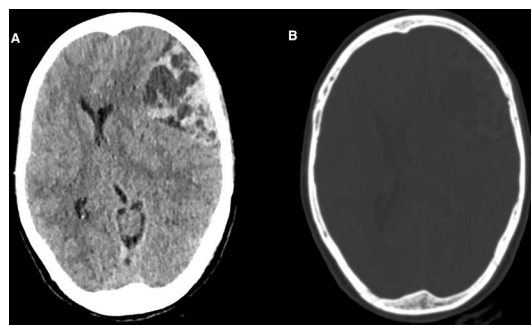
(A) Axial section non-contrast CT (NCCT) image of the brain shows a well-defined heterogeneously hyperdense multicystic broad dural-based extra-axial lesion in the left frontoparietal convexity. It exerts a mass effect in the form of effacement of the underlying cortical sulci and the left lateral ventricle along with the contralateral midline shift. (B) The axial bone window NCCT image of the head shows the normal overlying calvarial bones without evidence of erosion or sclerosis.
